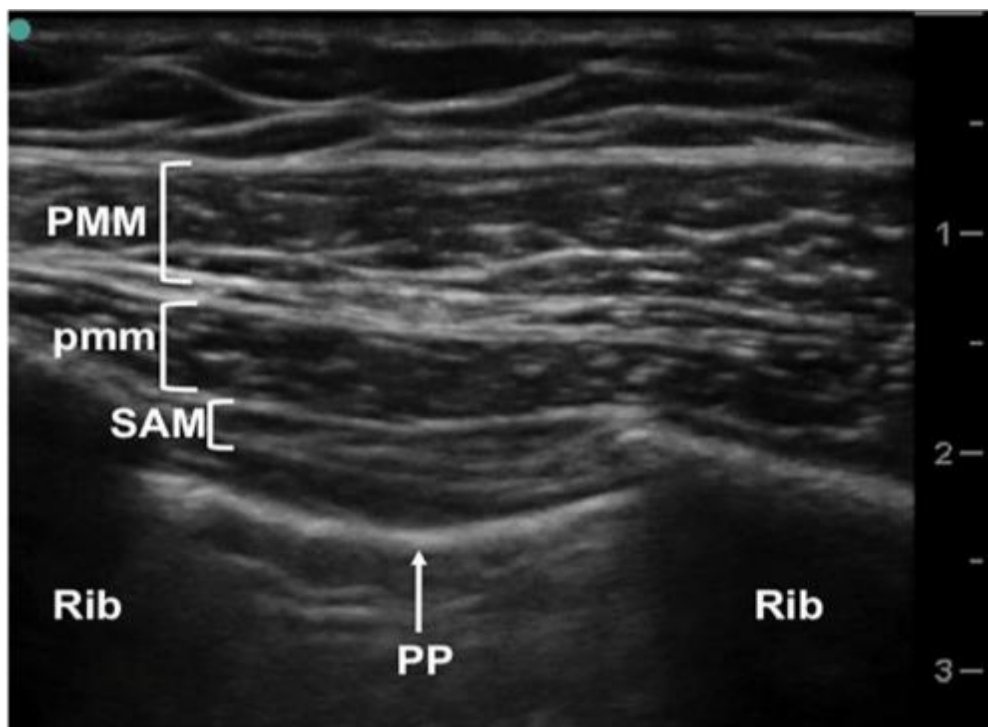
Ultrasound visualization for pectoral nerve block II. The pectoralis major muscle (PMM), pectoralis minor muscle (pmm), and serratus anterior muscle (SAM), and the parietal pleura (PP) is identified between the ribs (14).
